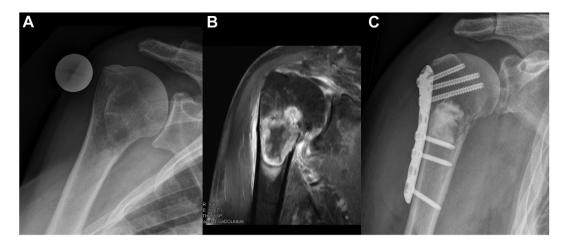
Case of a 53-year-old male patient with a renal cell carcinoma diagnosed 11 years before the fracture occurred. (A) Preoperative anteroposterior view showing osteolytic osseous metastasis metaphyseal below the humeral head. (B) Magnetic resonance imaging: Gadolinium-enhanced fat-suppressed T1-weighted coronal view showing bone metastases in the proximal humeral metaphysis with medial minimally compressed pathologic fracture. (C) Postoperative anteroposterior view after compound osteosynthesis. The bright, patch-like areas in the bone are cement-filled regions.
